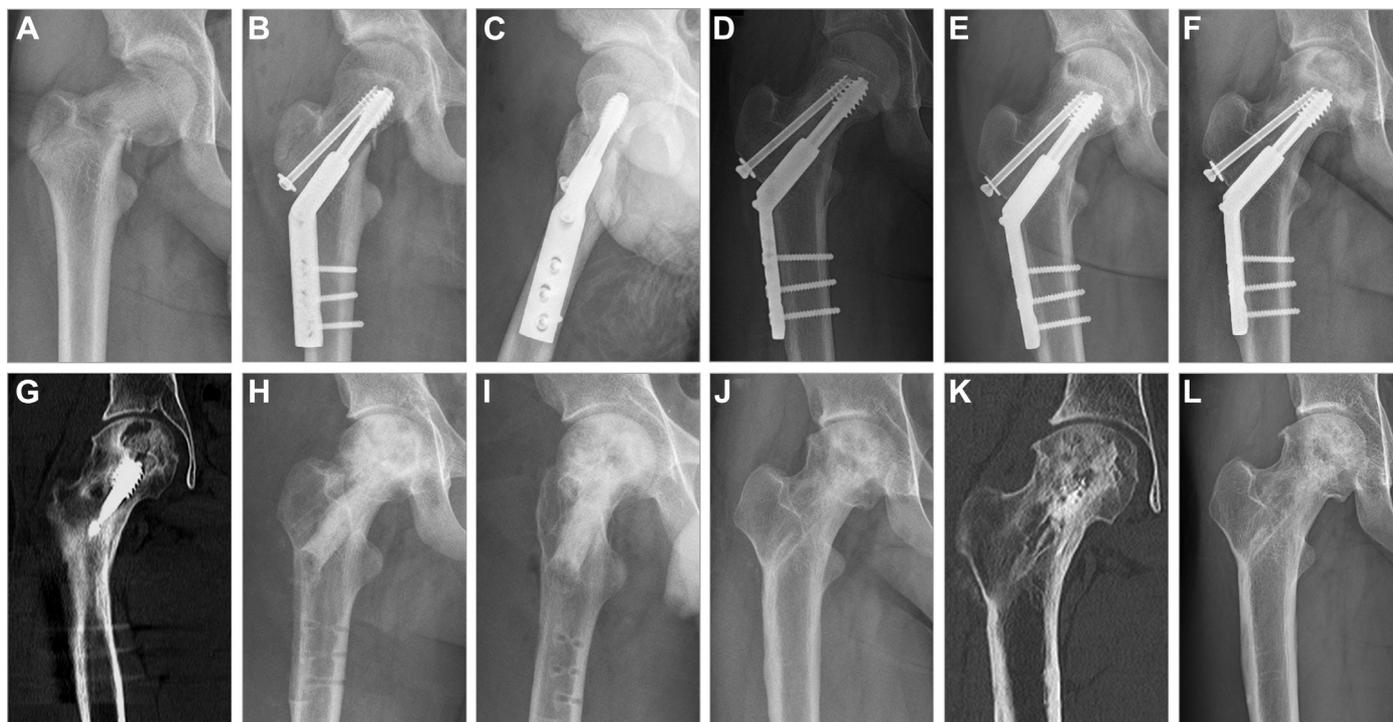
Representative radiographic images from an 18-y-old male patient treated with core decompression and PRP-incorporated autologous granular bone grafting. (A) X-ray shows a femoral neck fracture with comminution in the previous injury. (B and C) X-ray on the day of previous treatment with DHS fixation. (D and E) X-ray at 6 and 12 mo after DHS fixation for the femoral neck fracture. (F and G) X-ray and CT show ARCO stage III ONFH 18 mo after DHS fixation for the femoral neck fracture. (H and I) X-ray on the day of core decompression and PRP-incorporated autologous granular bone grafting. (J and K) X-ray and CT scans 12 mo after surgery show consistency. (L) X-ray at 36 mo after surgery shows no further advanced femoral head collapse or osteoarthritis. PRP, platelet-rich plasma; DHS, dynamic hip screw; CT, computed tomography; ARCO, Association of Research Circulation Osseous; ONFH, osteonecrosis of the femoral head.
